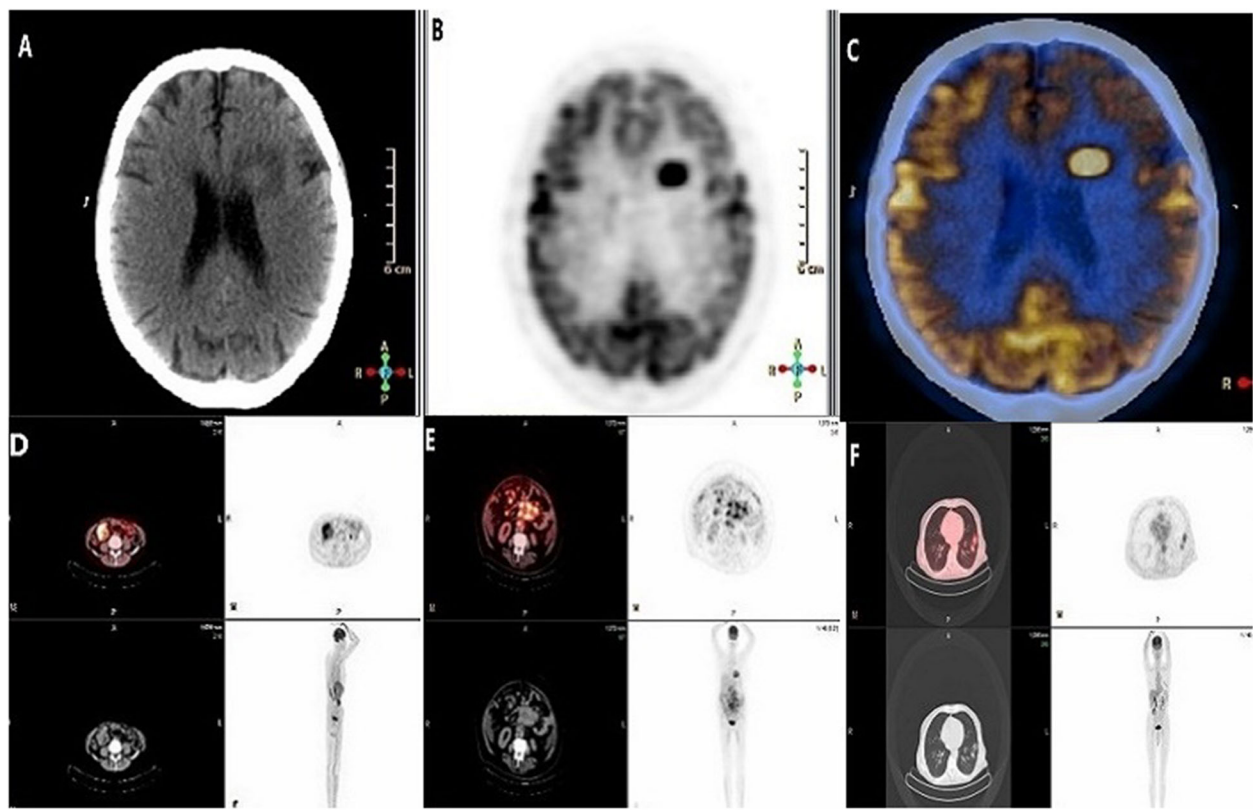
A 64-year-old patient with single metastatic mass lesion in left posterior frontal lobe. a–c Axial CT, PET, and fused PET/CT scan showed active solitary metastatic lesion seen in the left posterior frontal lobe. d Multiplanar fused PET/CT and PET scan showed a cecal mass with active uptake proved by colonoscopic biopsy to be adenocarcinoma of caecum. e Multiplanar fused PET/CT and PET scan showed multiple active retroperitoneal lymph nodes. f Multiplanar fused PET/CT and PET scan showed two metastatic active mass lesions in the left lung
